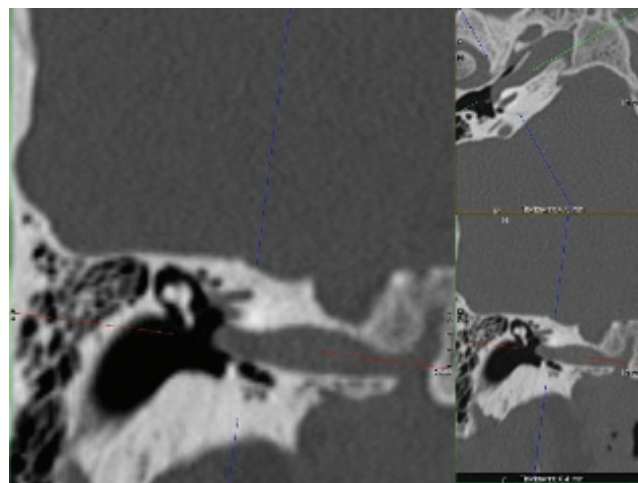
Coronal and axial CT with aberrant right ICA course, passing into middle ear cleft, just lateral to cochlear promontory.
